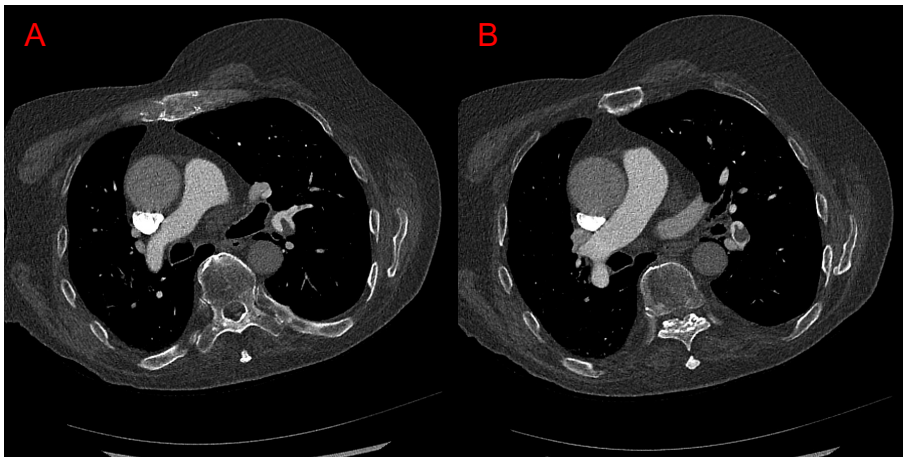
CASE 5: AXIAL CT WITH LARGE SEGMENTAL PE
